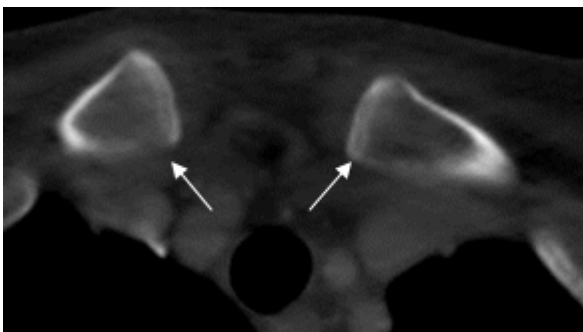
CT image of medial clavicles of a 22 year old male shows stage 4a ossification of bilateral epiphyseal cartilage (white arrows)
